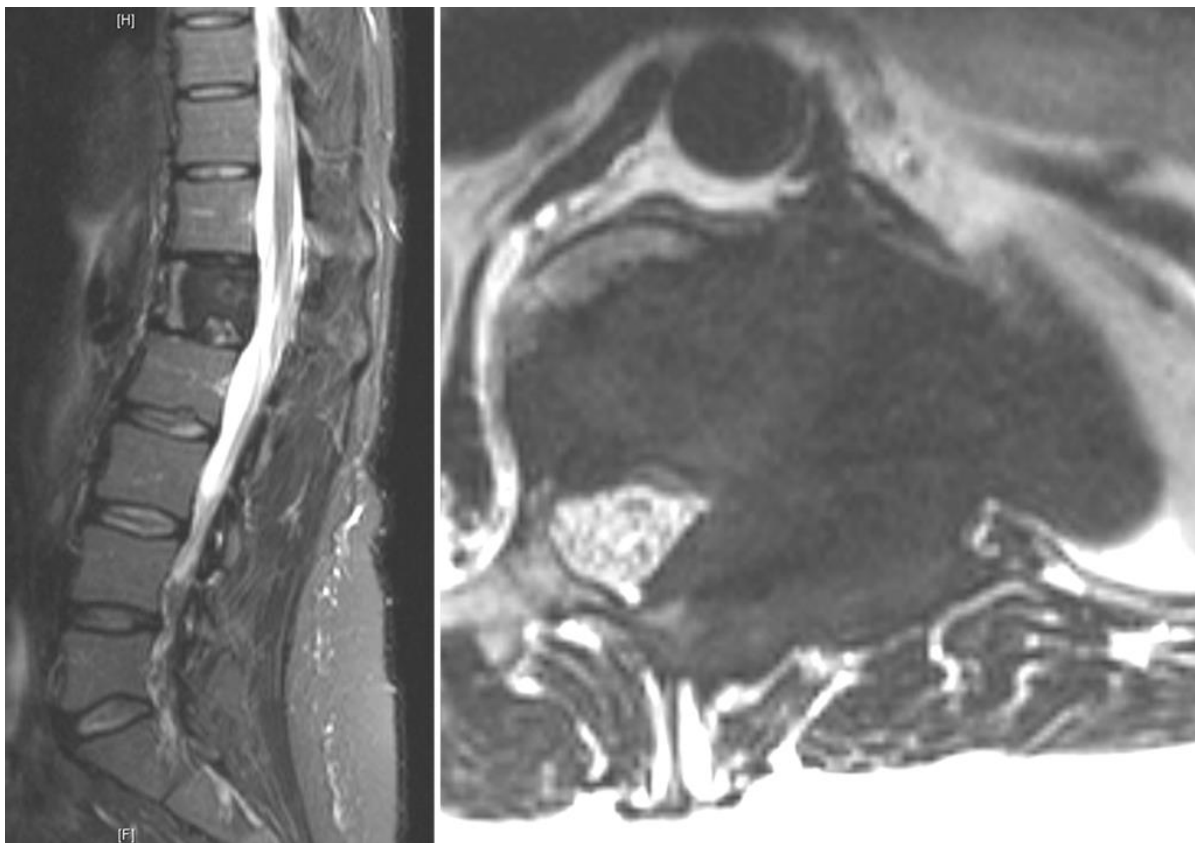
MRI demonstrating tumour shrinkage after neoadjuvant denosumab treatment
